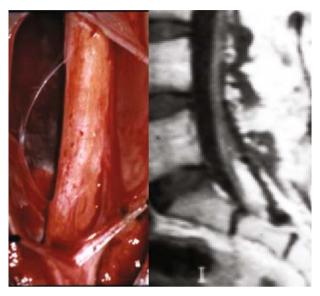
Lipomas of the filum. *On the left*, operative view of a lipoma involving the whole filum. *On the right*, MRI, T1 sagittal view, showing in another case a lipoma of the filum
